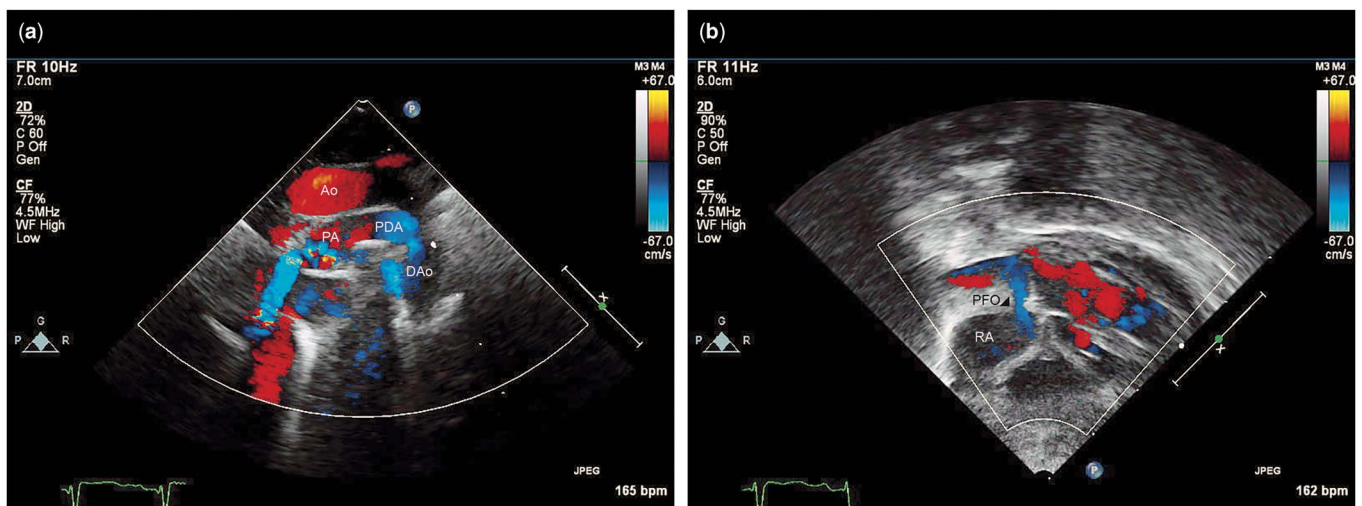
(a) Suprasternal notch long-axis colour flow Doppler view showing a patent ductus arteriosus (PDA) with evidence of pulmonary artery (PA) to descending aorta (DAo) flow. (b) Subcostal coronal colour flow Doppler view showing right atrium (RA) to left atrium flow across the patent foramen ovale (PFO). Both flow patterns may occur in the context of pulmonary hypertension.
